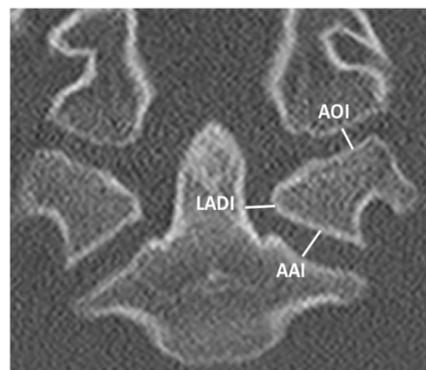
Coronal CT cervical spine demonstrating LADI, AOI, AAI
